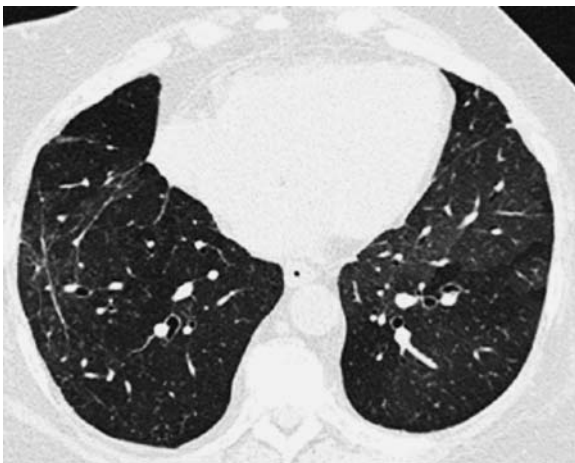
Transverse CT scan in double-lung transplant recipient with two sequentially performed single-lung transplants. Lungs of different donors in the same patient show different sizes and densities
